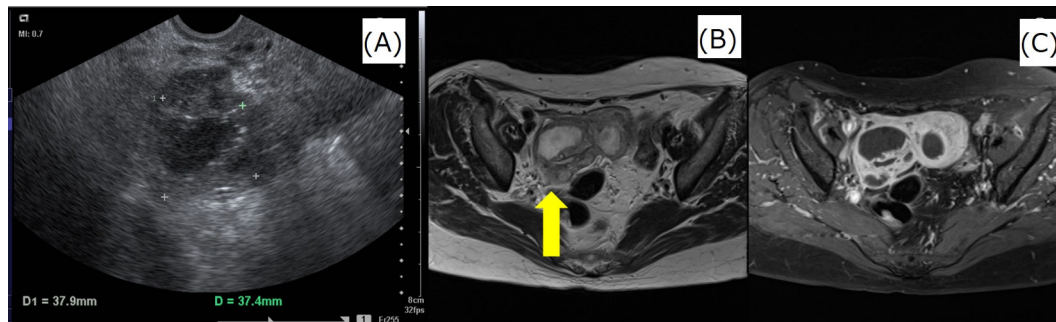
Images obtained at the first examination. Transvaginal ultrasound examination identified multiple cystic masses in the right adnexa. MRI revealed multiple cystic tumours with contrast effect and thickening of the right adnexal wall. (A) Transvaginal ultrasound, (B) MRI T2-weighted image and (C) MRI fat suppression gadolinium contrast T1-weighted image.
